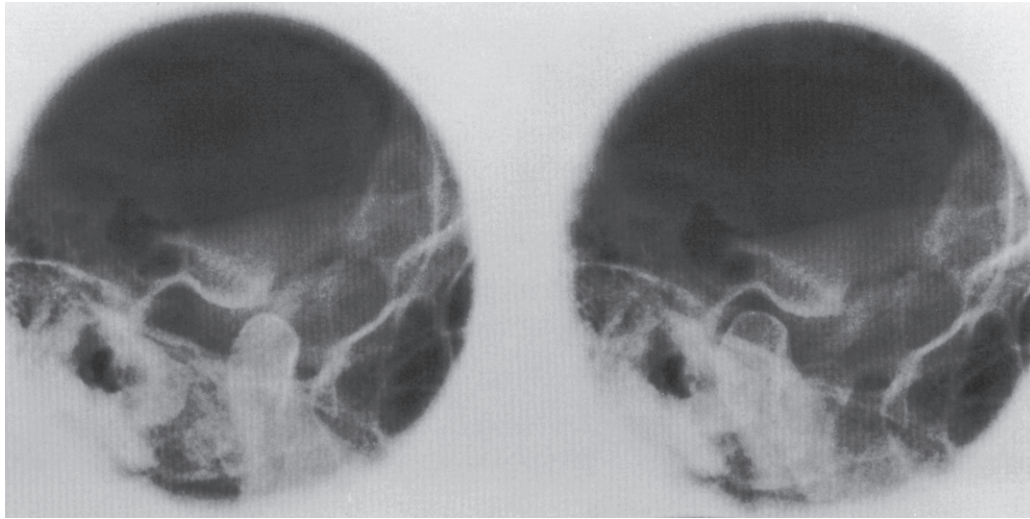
Radiograph showing the temporomandibular joint in open (*left*) and closed (*right*) position of mandible.
